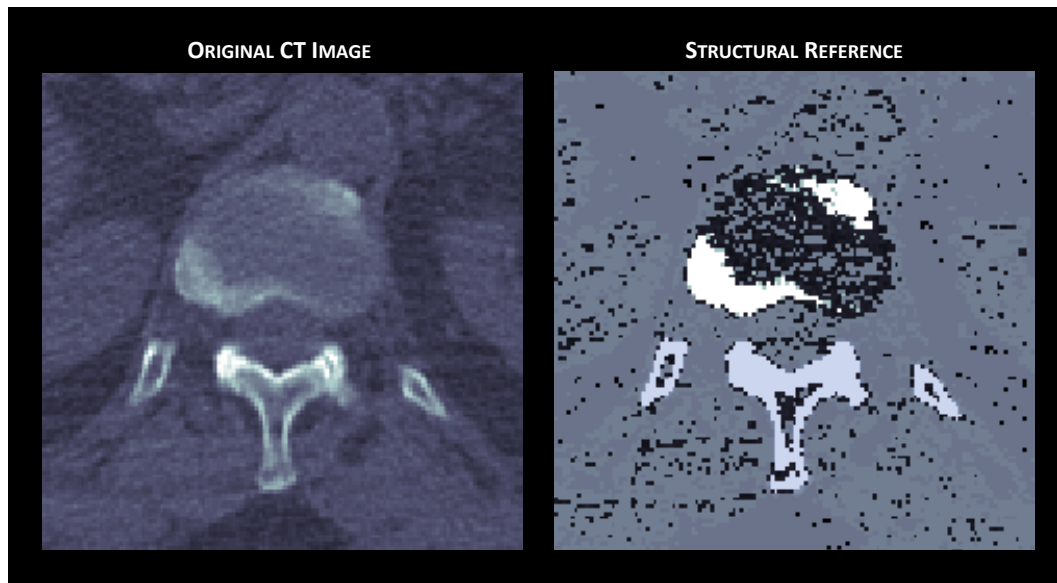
Comparison between the original CT image (left) and the structural reference image (right) for a zoomed transaxial spinal view. The ROIs of the structural reference are defined by automatic thresholding the original CT intensities in Hounsfield Units; the new value for each ROI is defined as the average activity of each corresponding region in the original PET image.
